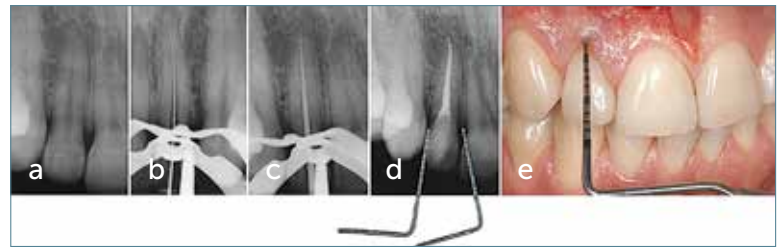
Endodontic treatment of a maxillary lateral right incisor due to a piercing trauma. (a) The initial case (necrotic tooth). (b) Working length. (c) Cone test. (d) End of the endodontic treatment: flowable resin barrier in a concave position over the gutta-percha (speed bleaching procedure); radiographic interproximal periodontal probing. (e) Vestibular periodontal probing of the Miller Class I recession present at the end of speed bleaching.
